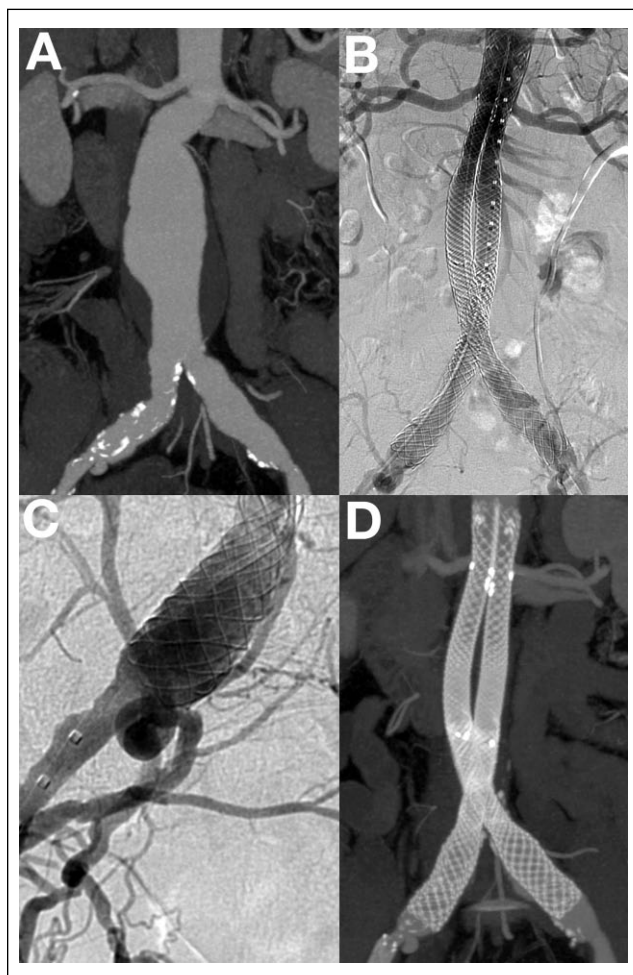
(A) Computed tomography angiography (CTA) of an abdominal aortic aneurysm with a 60° infrarenal angle, which was straightened immediately after placement of the Altura endograft (B). The 2 proximal D-shaped stents were positioned just below each renal artery to maximize use of the infrarenal neck. (C) Precise exclusion of the ectatic common iliac artery was achieved by deploying the iliac graft proximally from its distal position. (D) The 2-year CTA reconstruction demonstrated the stability of the device and a fully excluded aneurysm. At 3 years, the aneurysm size had decreased by 28 mm.
